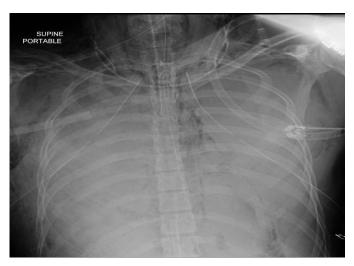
Chest radiography showed consolidation in the right lower and middle lobe with complete opacification and bilateral hemithorax; apically oriented bilateral chest tubes with end tracheal tube and NG tube in an appropriate position. (Multifocal pneumonia with ARDS)
